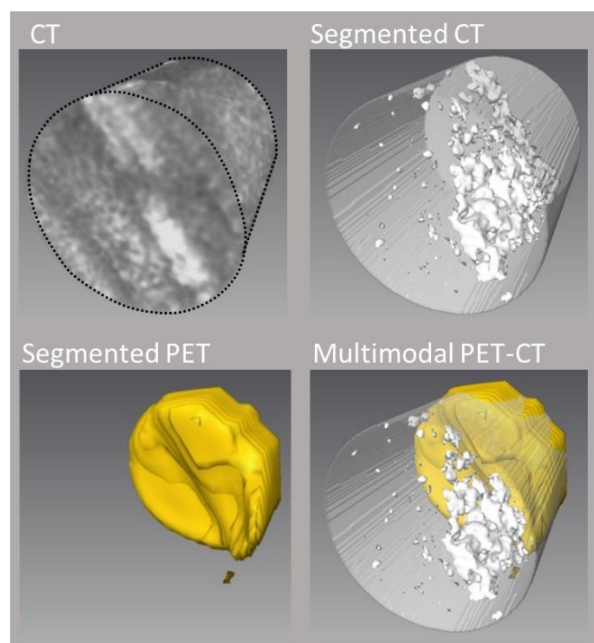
⁵. PET imaging captures the inflow of ¹¹C-¹⁸O₂ in tight shale. The nonuniform displacement front can be tied to structure, visible by CT. For in-depth discussion and results of the experiment showed in the figure we refer to [25].
